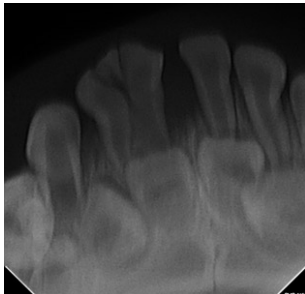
On intra-oral radiographic examination, the pulp chamber structure was obvious but a canal structure was not clearly seen for the supernumerary tooth.
